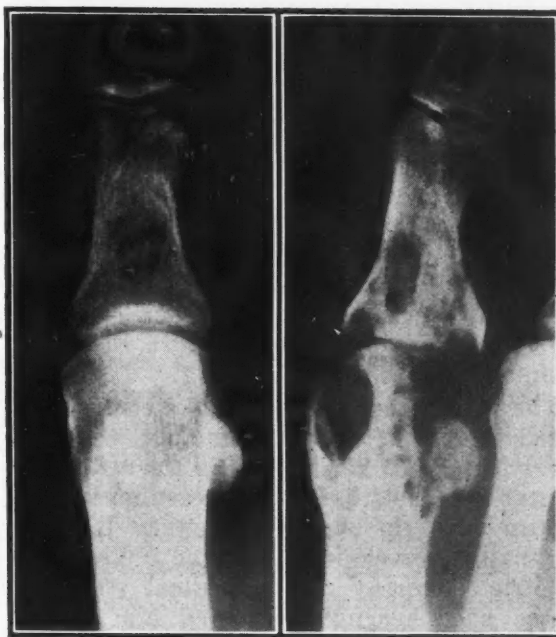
Roentgenogram of toe, taken July 13, 1932, when patient first noted discomfort.
